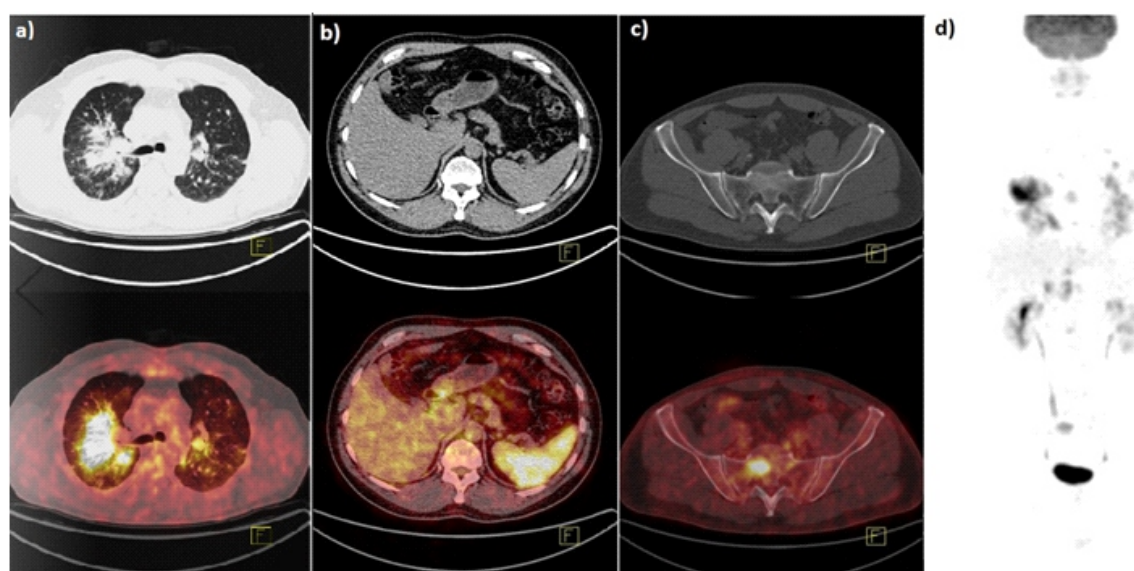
Hematogenic spread of seminoma in a 36 year-old after right side orchiectomy. Axial CT and PET/CT images: a) massive lung metastases b) spleen metastases; c) sacral bone metastasis; d) MIP (maximal intensity projection) (SUVmax=20.4) of the same patient.
